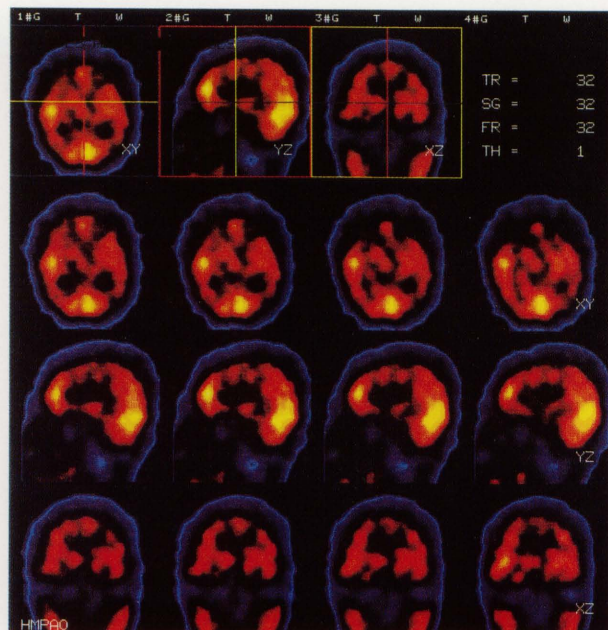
Interictally ^{99m}Tc -HMPAO SPECT scanning showing slight hypoperfusion of the left temporal lobe (Patient no. 8a).
